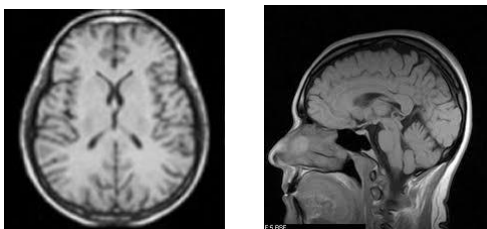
MRI scan for axial and sagittal view of brain (L-R) [29]
